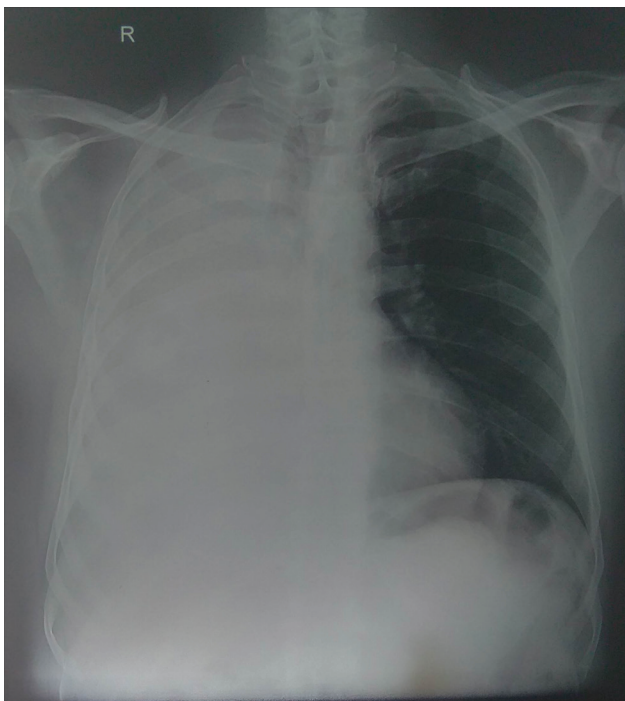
Chest X-ray PA view showing diffuse homogenous opacity without air bronchogram on right lung field
